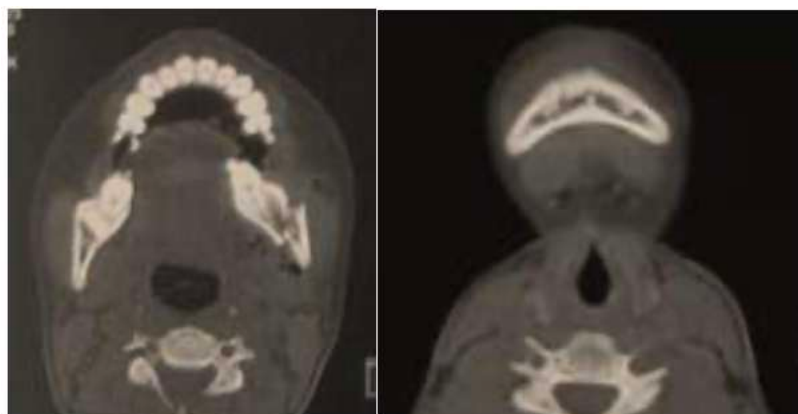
A CT scan of the head shows a discontinuity in the right para-symphysis of the mandibular bone and a discontinuity in the left corner of the mandibular bone.
